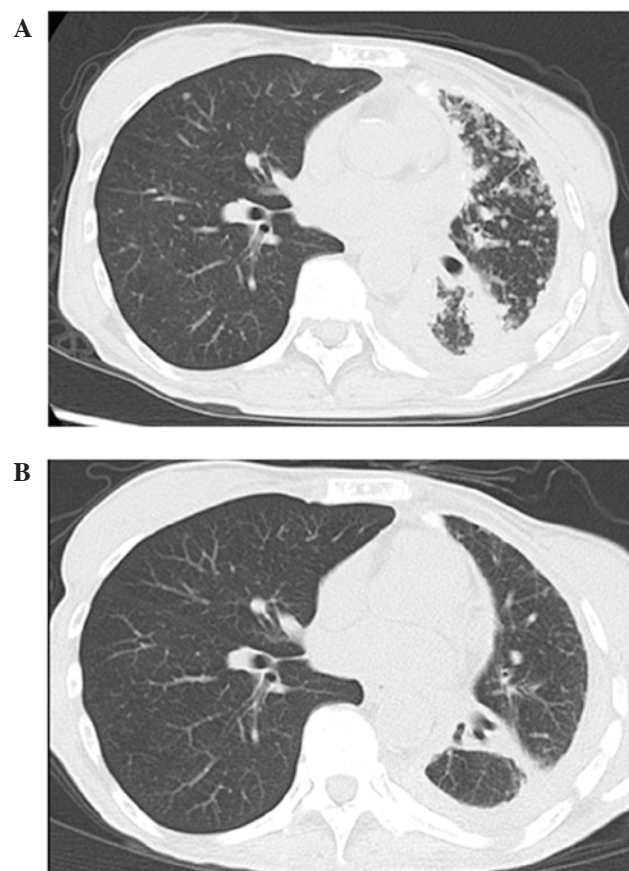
Chest computed tomography (A) prior to and (B) after treatment with osimertinib.
